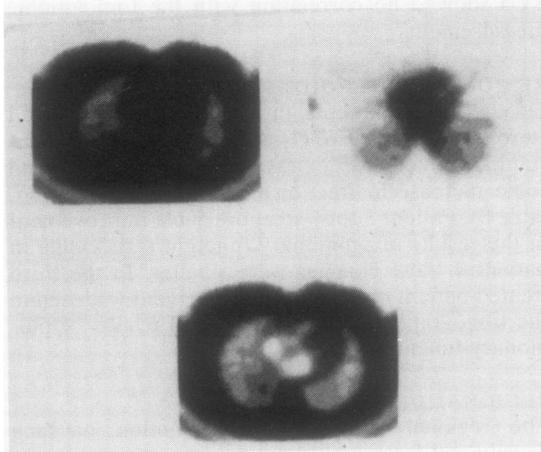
Chest radiograph (a) and tomograms (b) from a patient with sarcoidosis. Lung density (top left) is increased owing to an increase in extravascular lung density (bottom). Fractional blood volume (top right) is reduced in the dorsal part of the right lung field, which corresponds to the lower lobe.
